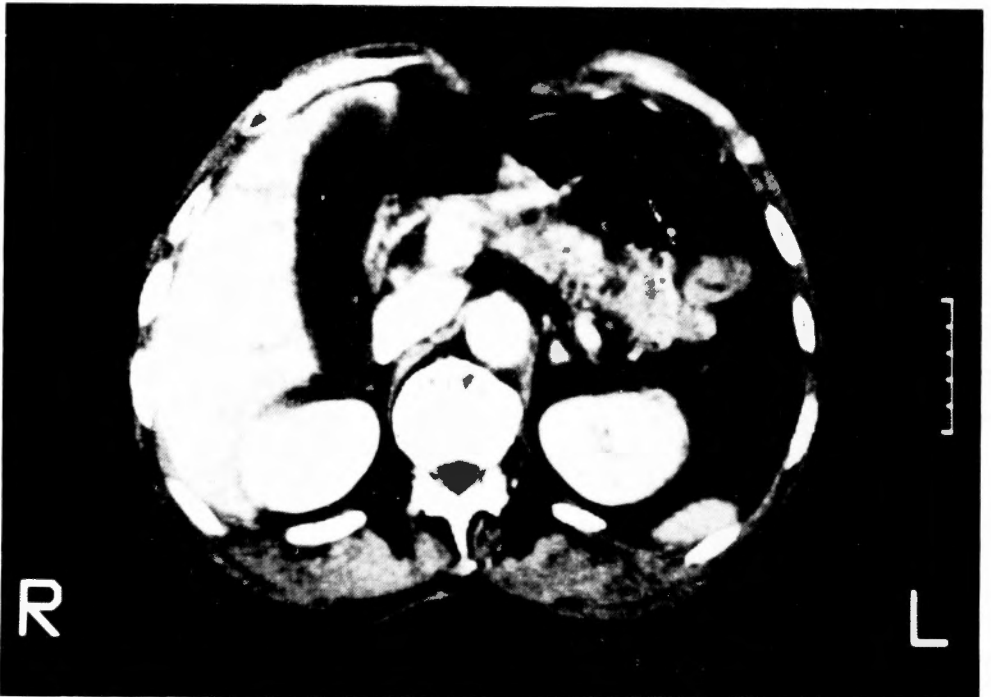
Abdominal CT scan shows an enlarged gallbladder with no evidence of a gallstone.
